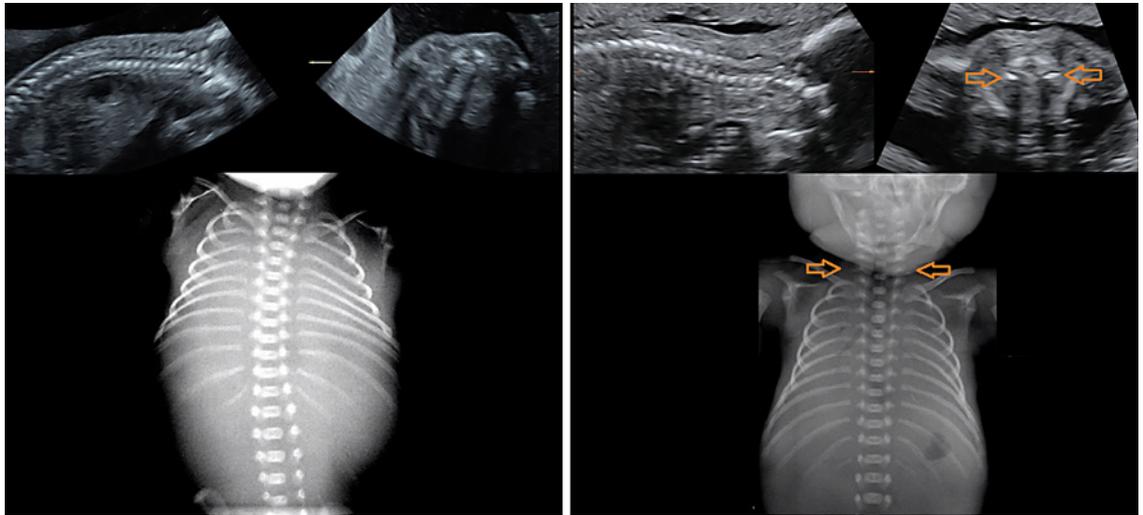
Example of sagittal and axial prenatal ultrasound images analyzed using 4DView and postnatal radiographic images of a fetus without (left) and with (right) bilateral rudimentary cervical ribs (orange arrows).
